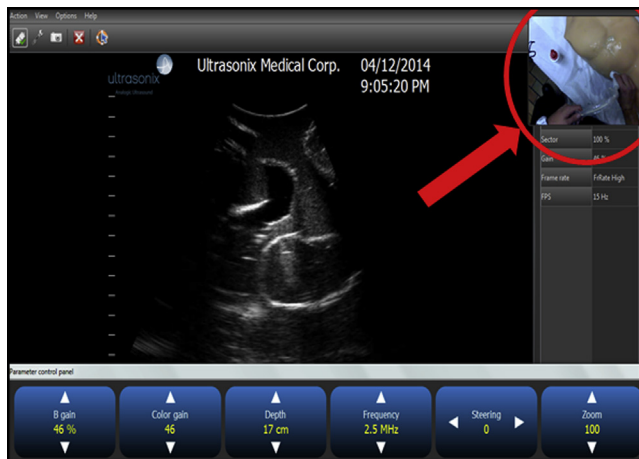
Visual ultrasound information presented to the remote mentor guiding the fire-fighters focused ultrasound examination. Large image depicts the graphic user interface as displayed on the remote mentors portable computing device. The red arrow and circle emphasize the display of the fire-fighters hands and ultrasound probe as imbedded onto the larger graphic user interface display. The imbedded window could be enlarged as desired by the mentor.
